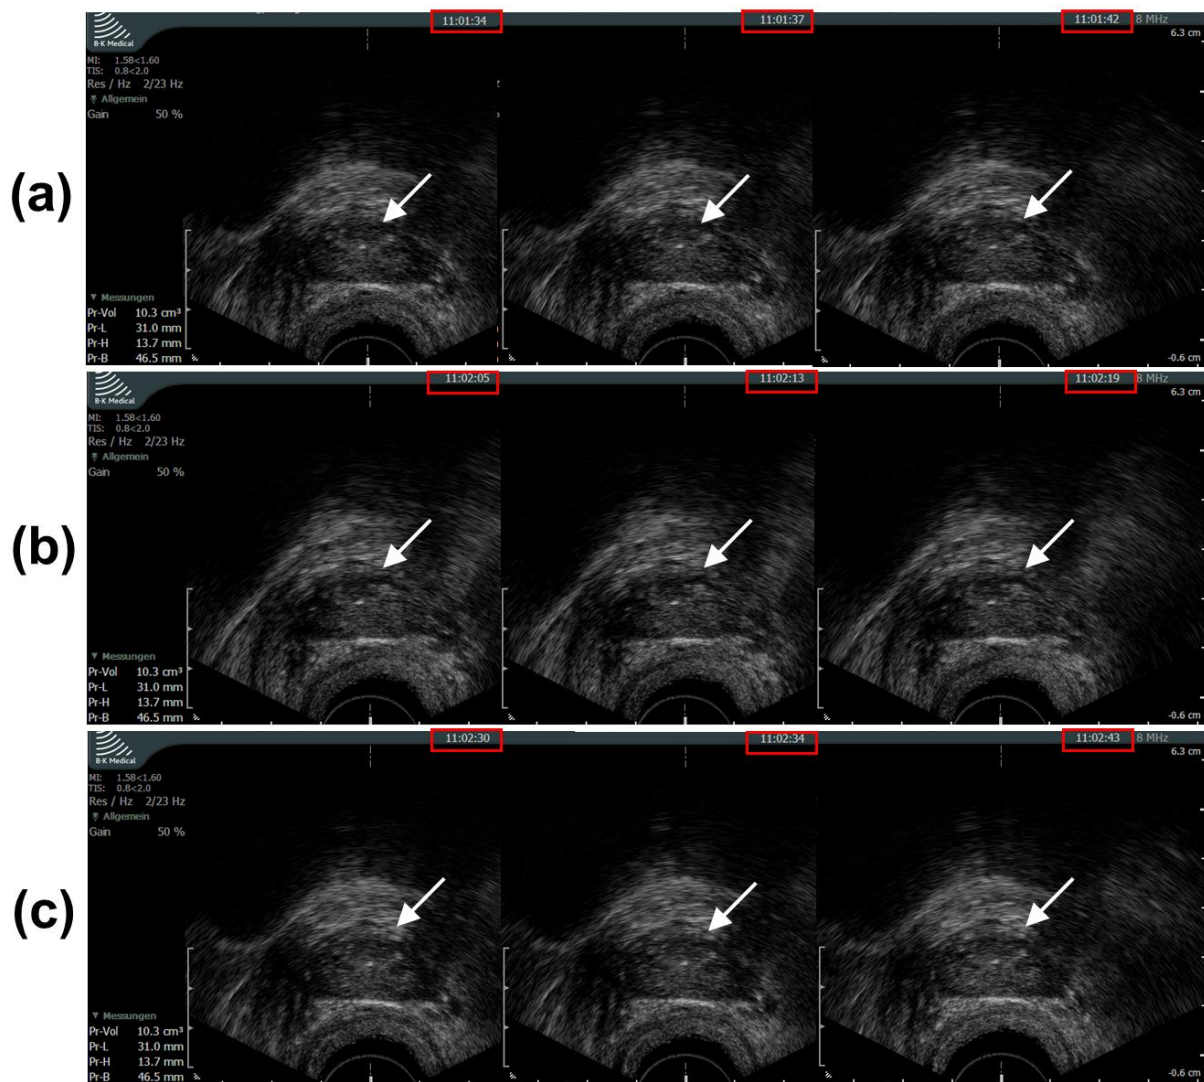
TRUS images of a cross-section 5 mm from the apex of the prostate (Pro Focus 2202 system, 8808 transducer, B-K Medical, Denmark). This cross-section was re-identified, even after repositioning the transducer, by correlating to Internal Landmarks on the scale of millimeter (*white arrows*). The visually identical TRUS images were obtained within one single AI-US-CT session, but respectively by three operators at different times (*red boxes*). (a) By doctor 1. (b) By doctor 2. (c) By doctor 3.
